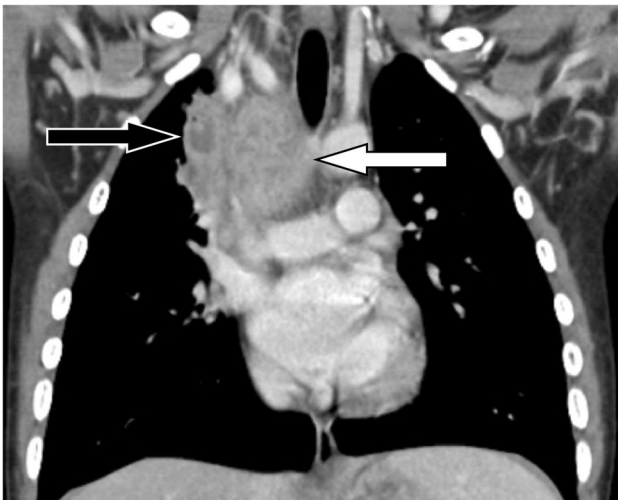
7-year-old boy with active coccidioidomycosis. Coronal reformatted chest CT image with IV contrast material shows heterogeneously enhancing, conglomerate mediastinal lymphadenopathy (white arrow), including a right upper mediastinal lymph node with discrete central necrosis (black arrow)
